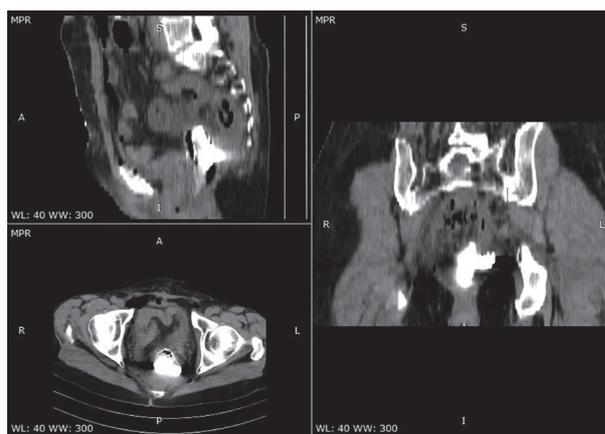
CT with rectal water soluble contrast in patient with AL
